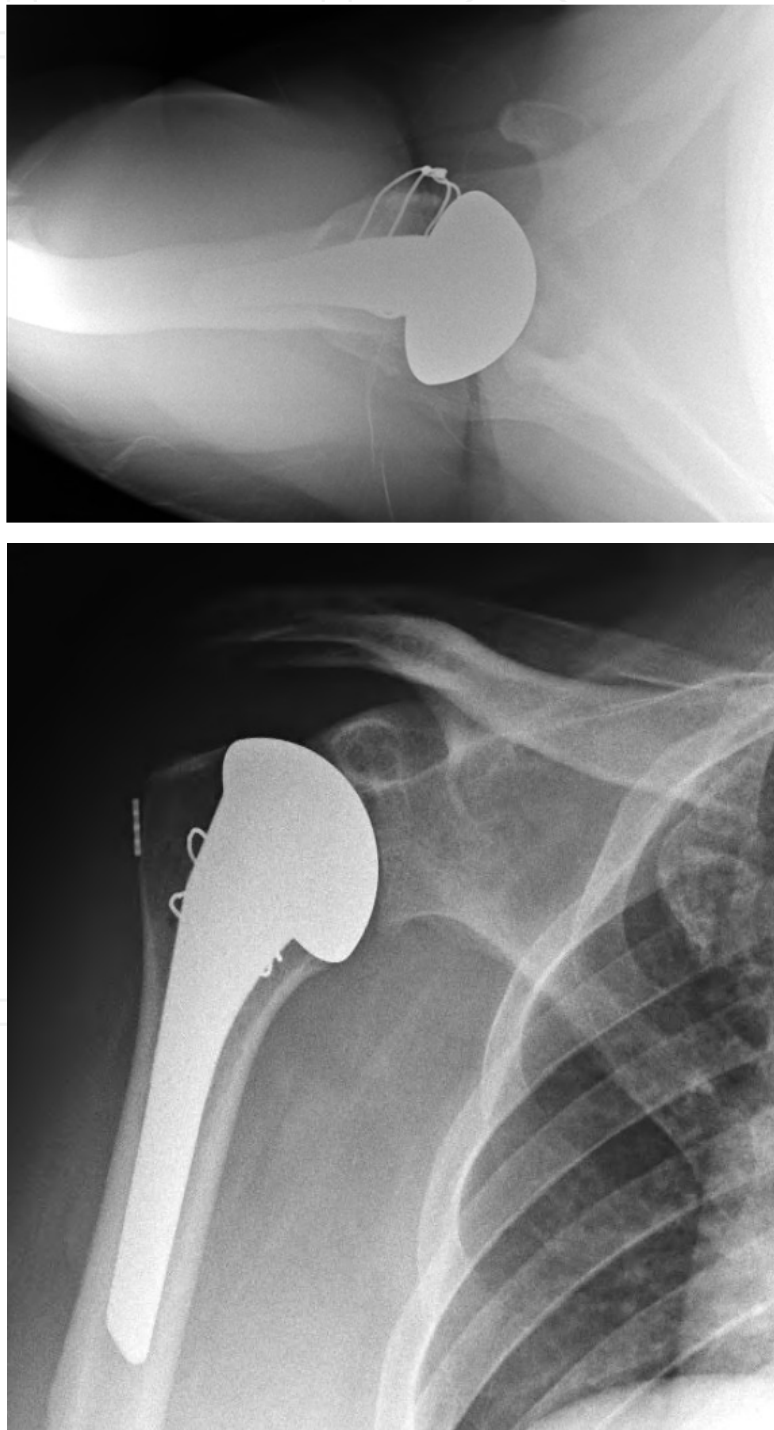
A and B: Postoperative AP and axillary lateral radiographs demonstrating anatomical reconstruction of the humerus with creation of a smooth concavity.
